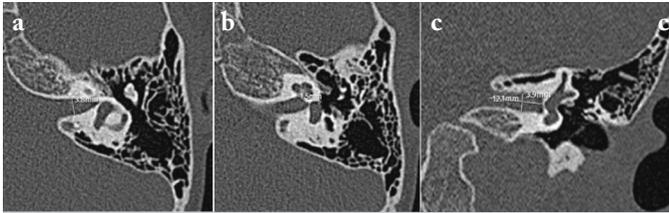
Temporal bone CT images showing the measurements of a) the width of internal auditory canal on transverse plane; b) the width of bony cochlear nerve canal on transvers plane; c) the length and height of internal auditory canal on coronal plane
